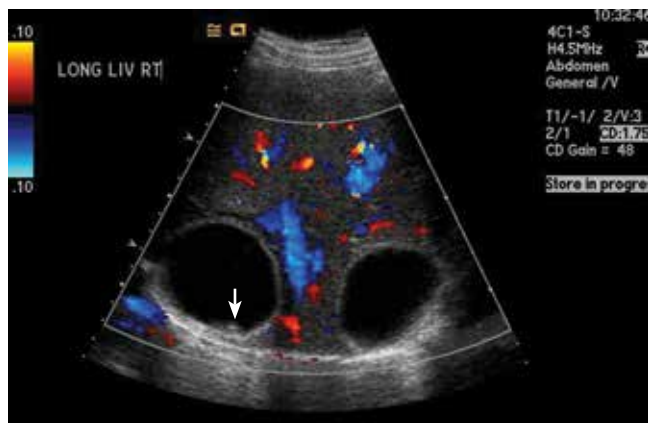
Ultrasonography of the liver shows two large, anechoic hepatic cysts with thickened walls and internal debris (arrow).
